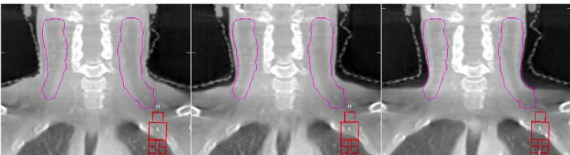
Example of visible progressive anatomical changes in soft tissue: tumor shrinkage/weight loss in the neck area (coronal view). The cone beam computed tomography scans were taken at Day 1, 18, and 55. No significant time trends in bony anatomy displacements could be determined for this patient.
